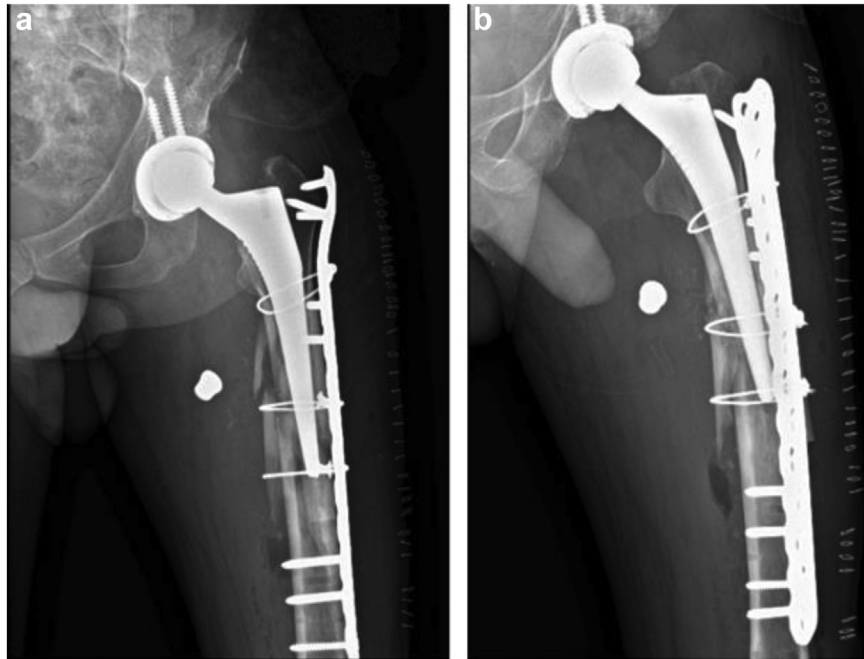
(a) Postoperative anteroposterior and (b) oblique proximal femur radiographs show fixation, as described. Note the unicortical screws proximally.
